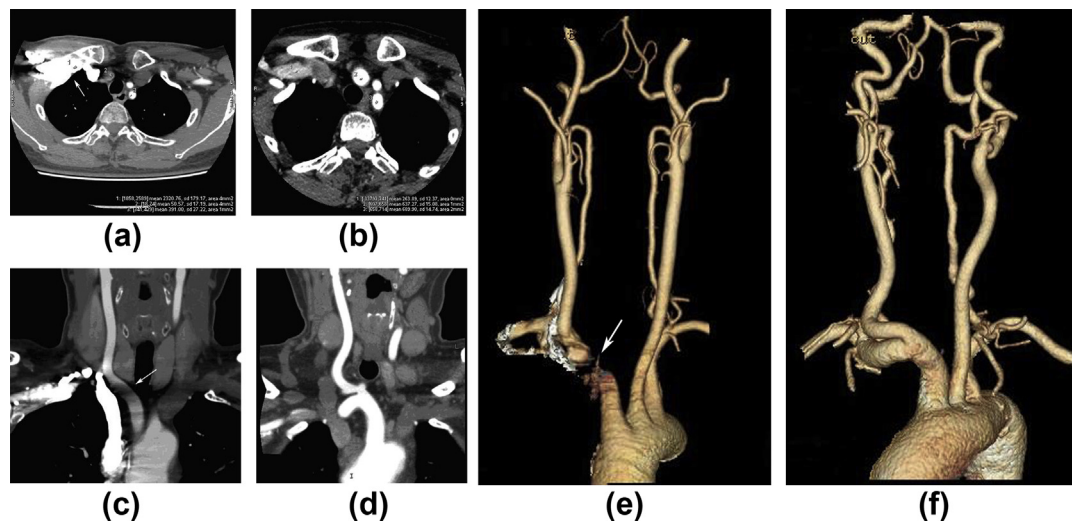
(a, c, e) CTA images of a 55-year-old woman using 370 mg iodine/kg contrast medium dose, 120 kV, and 400 mAs. (b, d, f) CTA images of a 62-year-old woman using 175 mg iodine/kg contrast medium dose, 80 kV, and 600 mAs. (a) Attenuation of peri-venous by streak artefacts reach 2320.76 HU. The attenuation of the innominate artery was only 50.57. (c, e) MPR and VR images of the innominate artery displayed poorly because of peripheral venous streak artefacts. (b) The attenuation of the right subclavian vein (264.89 HU) was much lower than that of the brachiocephalic trunk (637.27 HU), eliminating the venous streak artefacts. (d, f) MPR and VR images showing the innominate artery displayed perfectly.
